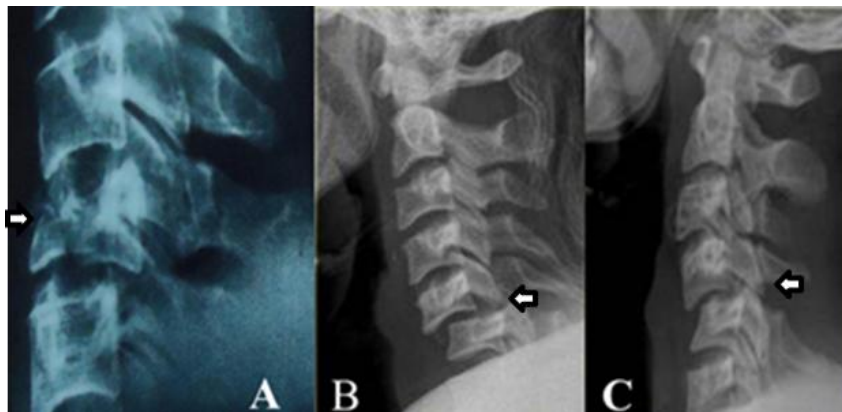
Lateral X-ray: A/ fracture of C5 vertebral body; B/ dislocation at C5-C6 level; C/ dislocation at C4-C5 level
